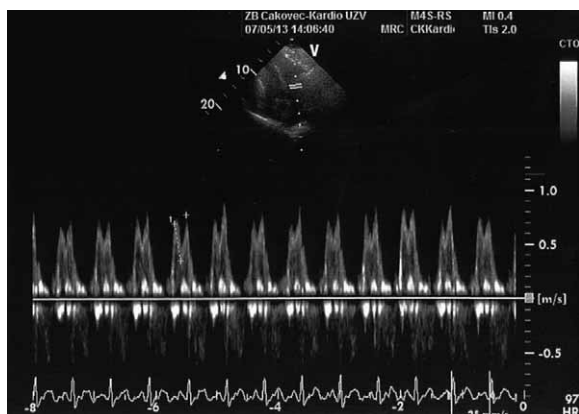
Follow-up echocardiogram one month later, Doppler recording of the mitral inflow velocity in patient described in Fig. 2., showing no respiratory variations in transmitral inflow, consistent with resolution of constrictive hemodynamics.
